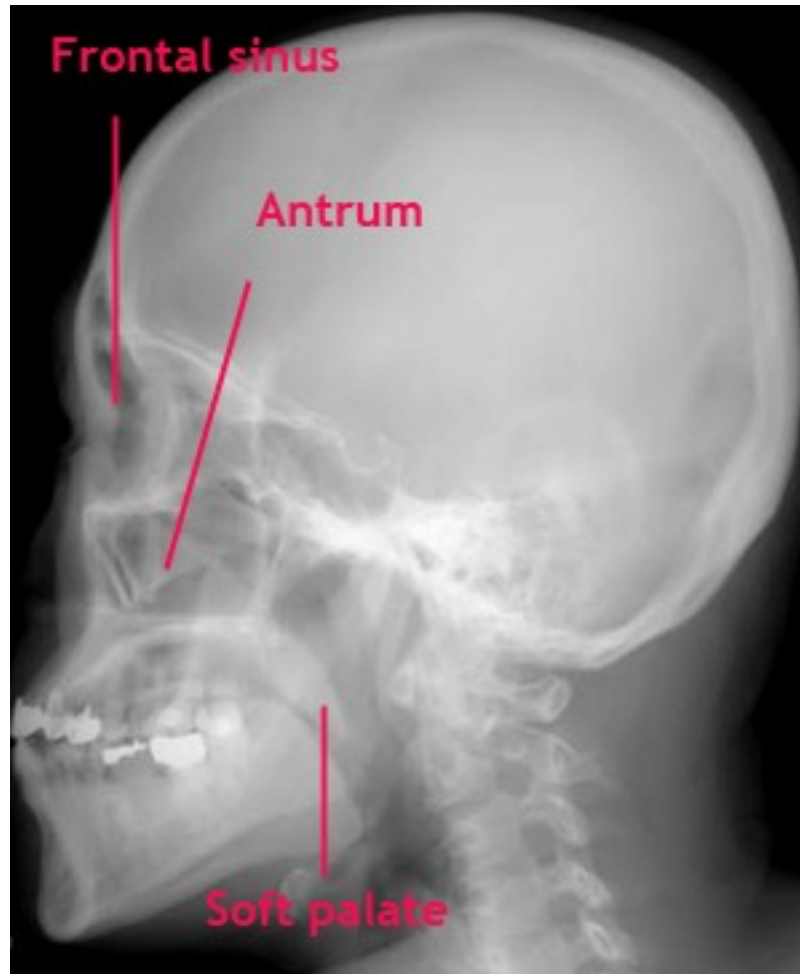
Figure showing skull position for xray skull lateral view
